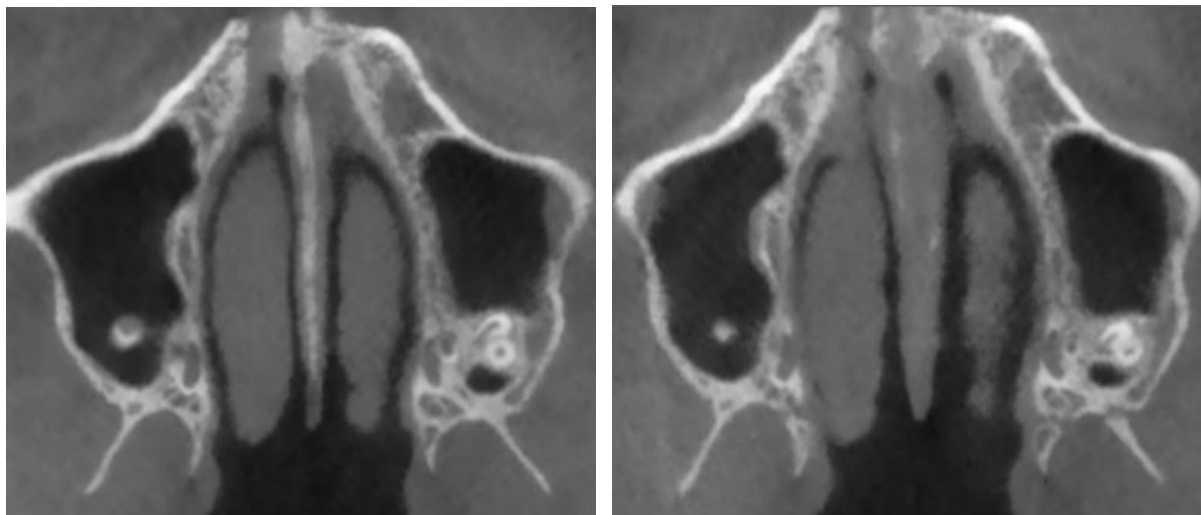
Openings between the lateral and medial plates of the pterygoid process detectable in the post-expansion CBCT in MSE patient. A: pre-expansion. B: post-expansion.
